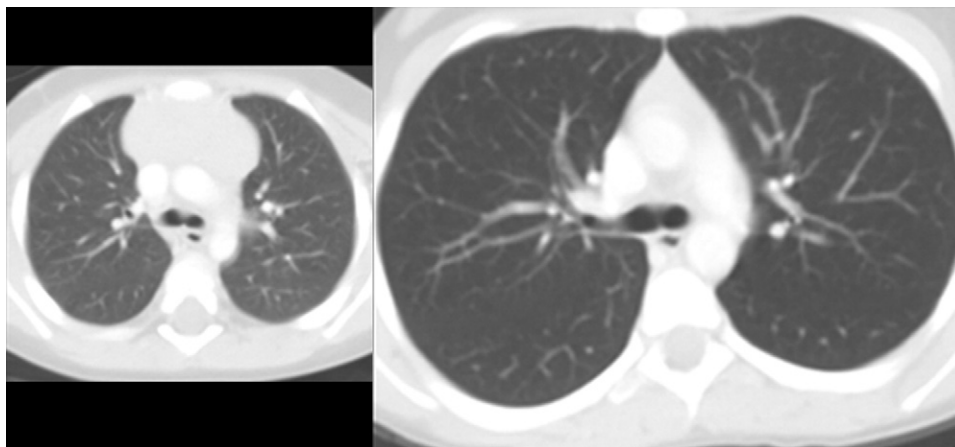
Representative axial unenhanced CT images from 6-year and 19-year old subjects demonstrate increase in mean lung volume with increasing age in pediatric subjects.
